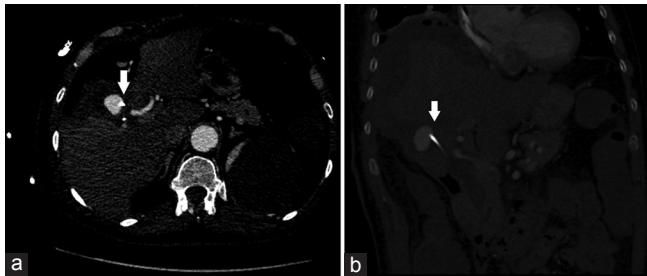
Computed tomography angiogram. Coronal (a) and axial (b) images demonstrate the hepatic artery pseudoaneurysm before embolization, with the biliary stent abutting its walls (arrow)
